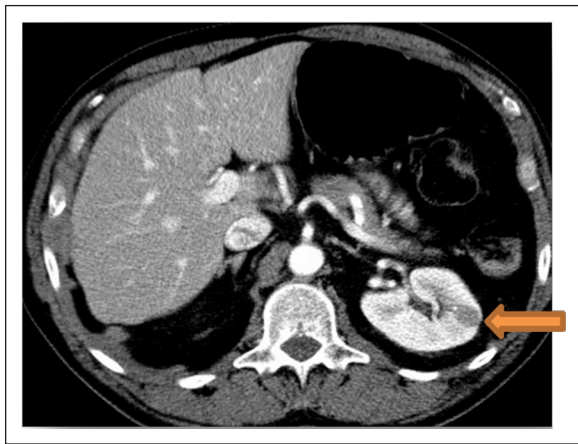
A CT abdomen done on 26 January 2011 showing non-enhancing 1.5-cm low-density focus within the lateral mid-pole of the left kidney (Yellow Arrow), no additional renal mass identified.
